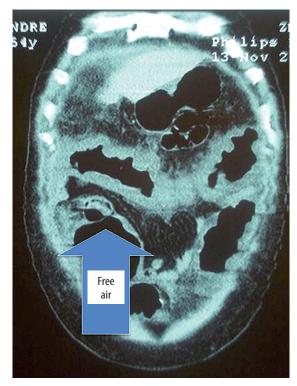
Coronal view of computed tomography abdomen showing dilatation of the cecum (16 cm), thickened colon wall (4–6 cm), free air in the cecum and ascites
